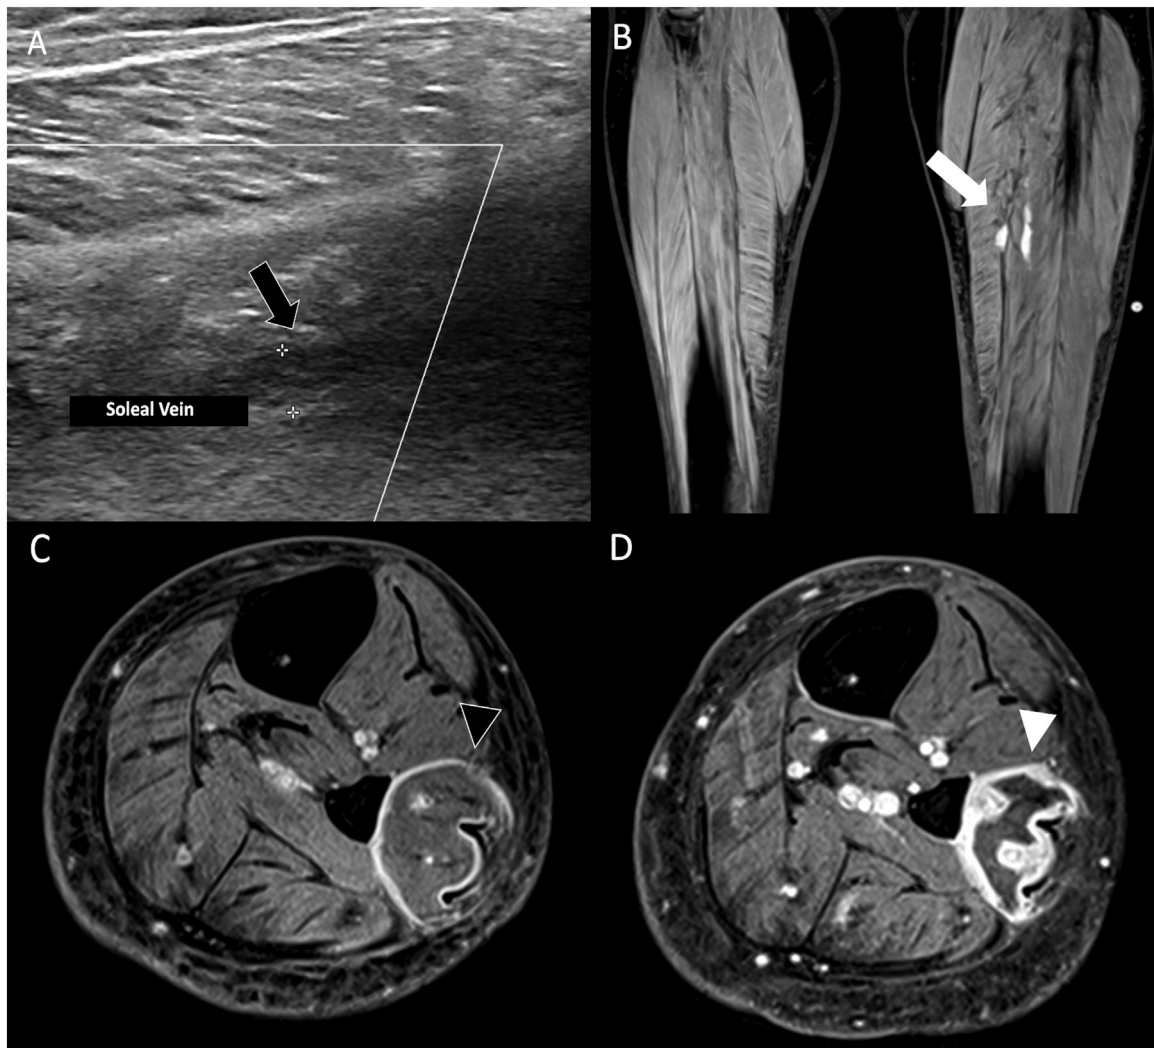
Myonecrosis secondary to deep vein thrombosis. (A) Color Doppler ultrasound showing thrombosis without recanalization of the soleal vein (black arrow). (B and C) Baseline MRI demonstrating an acute thrombus with high signal on coronal T1-weighted imaging with fat saturation, in the posterior tibial and soleal veins, compatible with acute thrombosis (white arrow), as well as an area of muscular bulging, associated with peripheral contrast-enhancement in the corresponding muscle, on axial T1-weighted imaging with fat saturation, after intravenous gadolinium injection (black arrowhead). (D) Follow-up MRI, performed 1 month after the initial scan, showed a decrease in the muscle volume, loss of definition of the muscle fibers and persistence of the peripheral contrast-enhancement (white arrowhead), compatible with myonecrosis.
